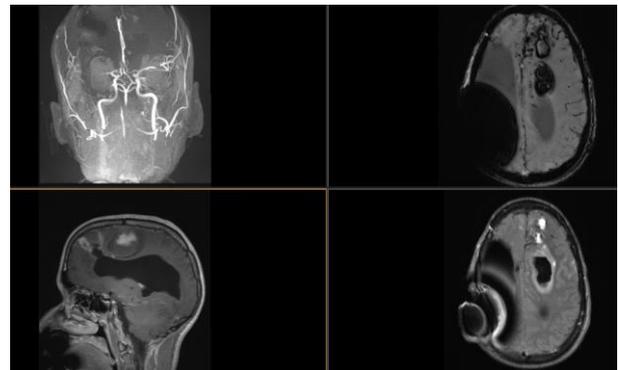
MRI/MRA consistent with cerebral amyloid angiopathy but not vasospasm. SWI imaging with classic presentation for CAA.
